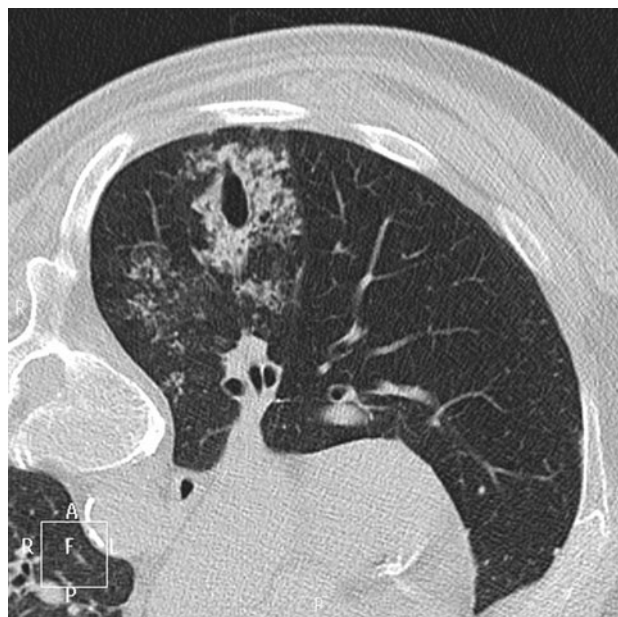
A 67-yr-old woman with a multinodular goiter who underwent surgery for a total thyroidectomy presents with blood coming out of the endotracheal tube after intubation. A) The thoracic computed tomography (CT) scan (coronal reformation) shows ectasia of the subsegmental B8 bronchus (9 mm in diameter) surrounded by
